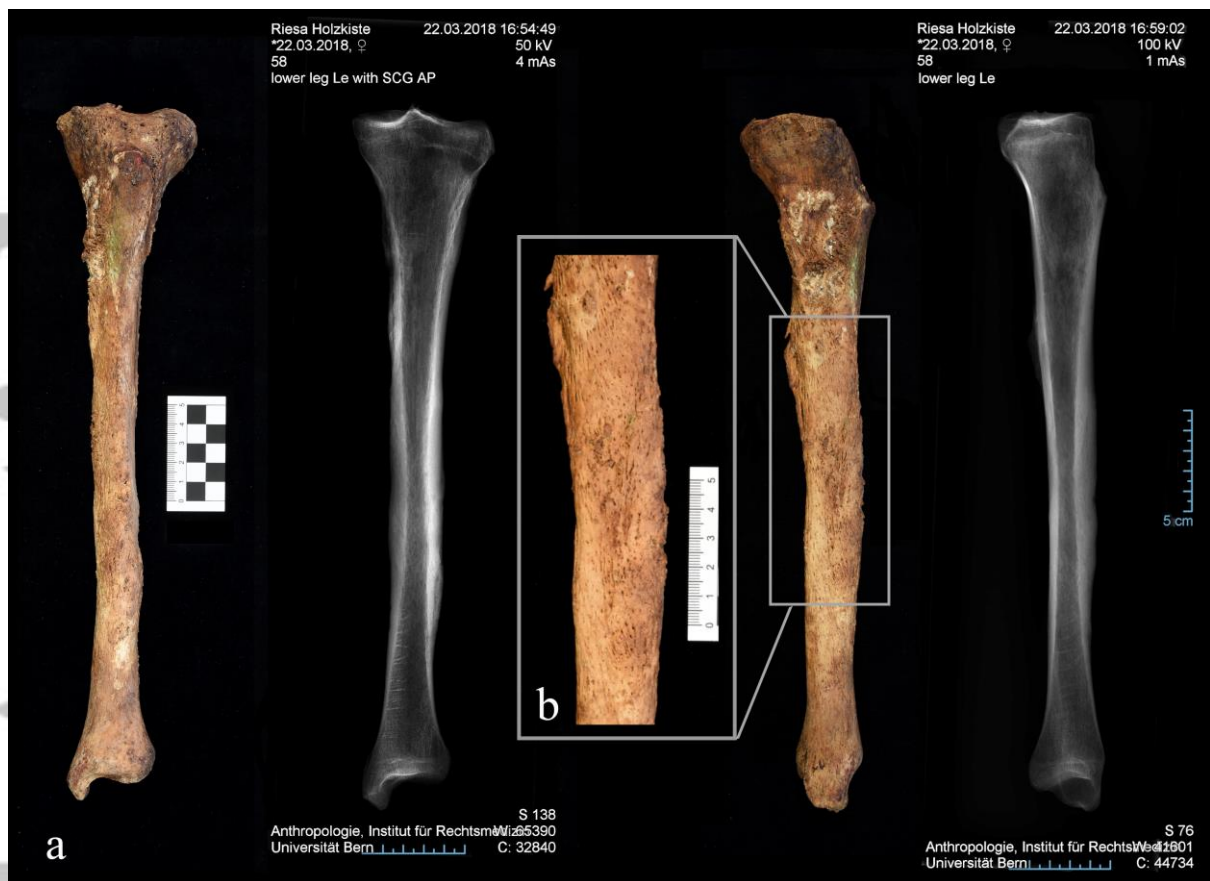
Overview a) Anteroposterior and mediolateral photographs and corresponding radiographic images of the left tibia, showing extensive new bone formation on the medial and the lower lateral diaphysis. Detail b) Close-up photograph of the periosteal changes of the tibia, showing woven as well as remodelled bone.
